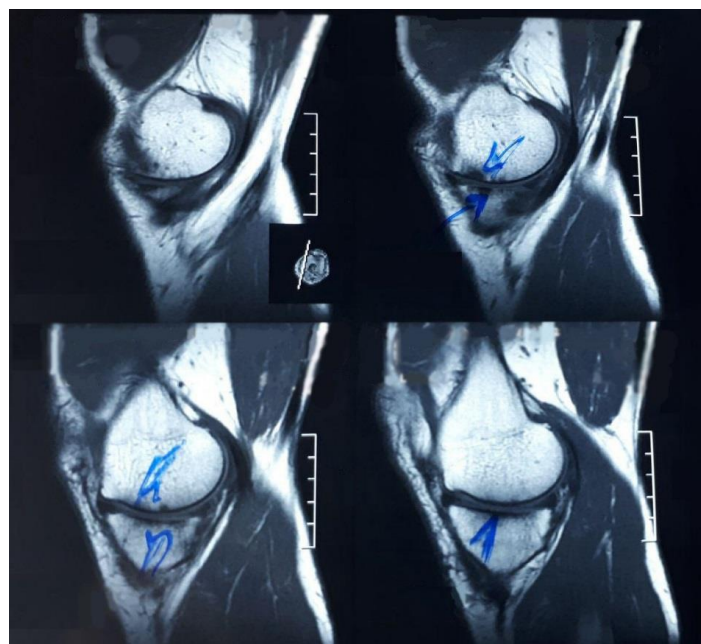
Magnetic resonance imaging (MRI) scanning before (Up) and after (Down) treated with Adipose tissue-derived stem cells /Platelet-rich plasma
